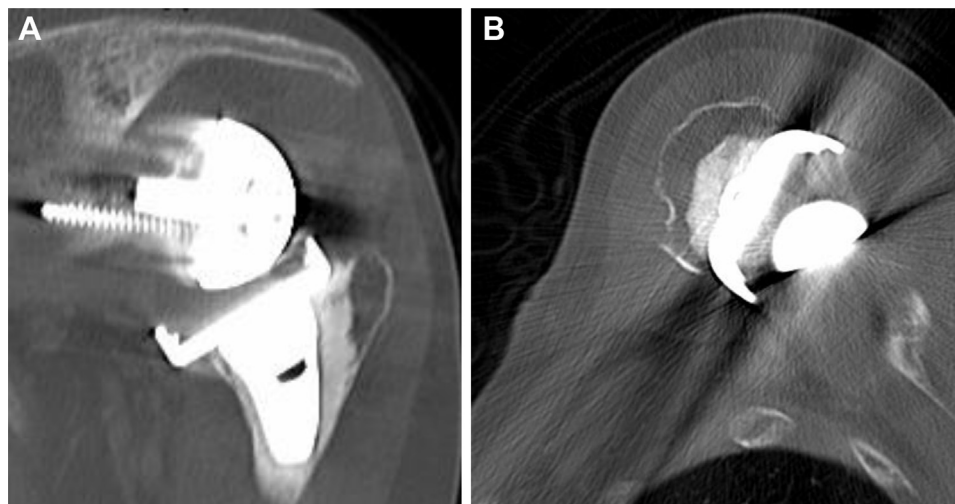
(A) Initial CT coronal view showing abundant bone stock at the greater tuberosity. (B) Initial CT axial view showing abundant bone stock at the greater tuberosity.
